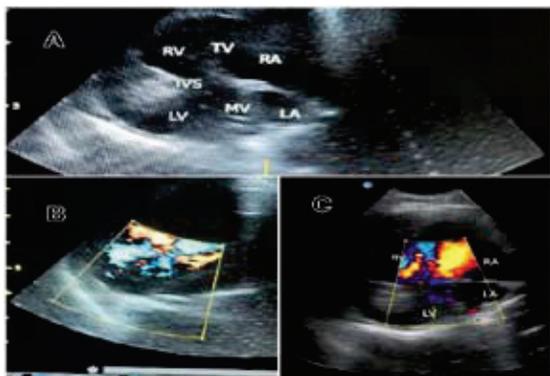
Echocardiographic picture showing enlarged left ventricle (LV), left atrium (LA), right ventricle (RV) and right atrium (RA). B mode echocardiography displaying intraventricular septal defect (IVSD) (A). Colour doppler echocardiogram shows IVSD (B) and severe tricuspid regurgitation (C).
